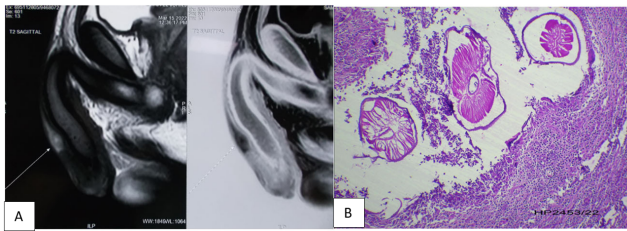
A): MRI coronal section of the T1 & T2 phase showing the lesion; B): HPE showing the helminthic worm with thick cuticle and muscle layer surrounded by abscess with inflammatory granulation tissue
